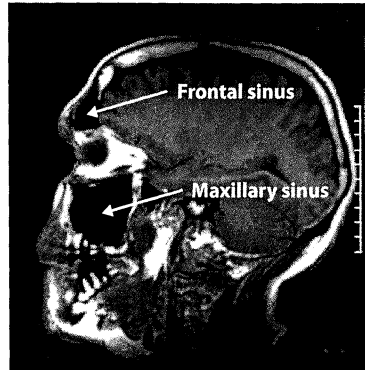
MRI image of a human head with the maxillary and frontal sinuses indicated.*
